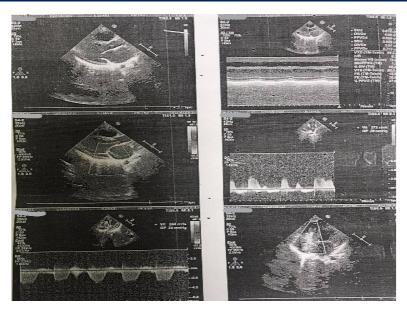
Echocardiographic appearance of myocarditis
